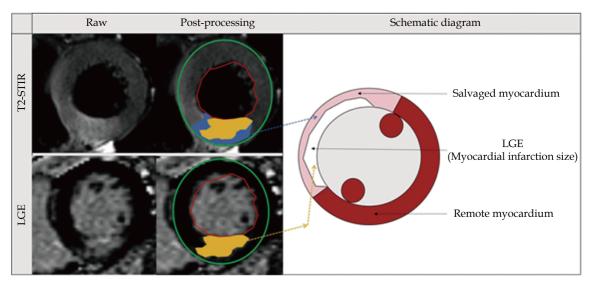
Cardiovascular magnetic resonance images of area at risk, myocardial salvage and final infarct size. LGE: late gadolinium enhancement.
